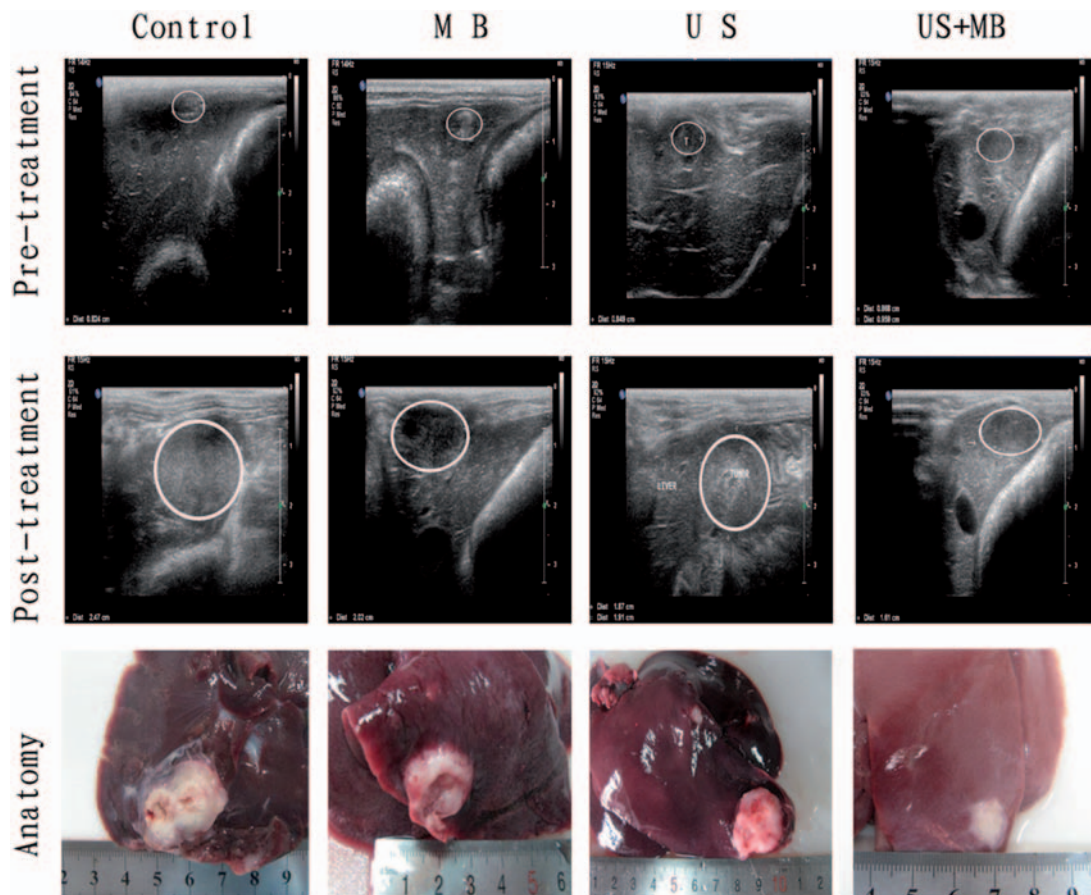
Representative ultrasound images prior to and following treatment and anatomies of tumors in the control, MB, US, and US + MB groups. (A color version of this figure is available in the online journal.)
